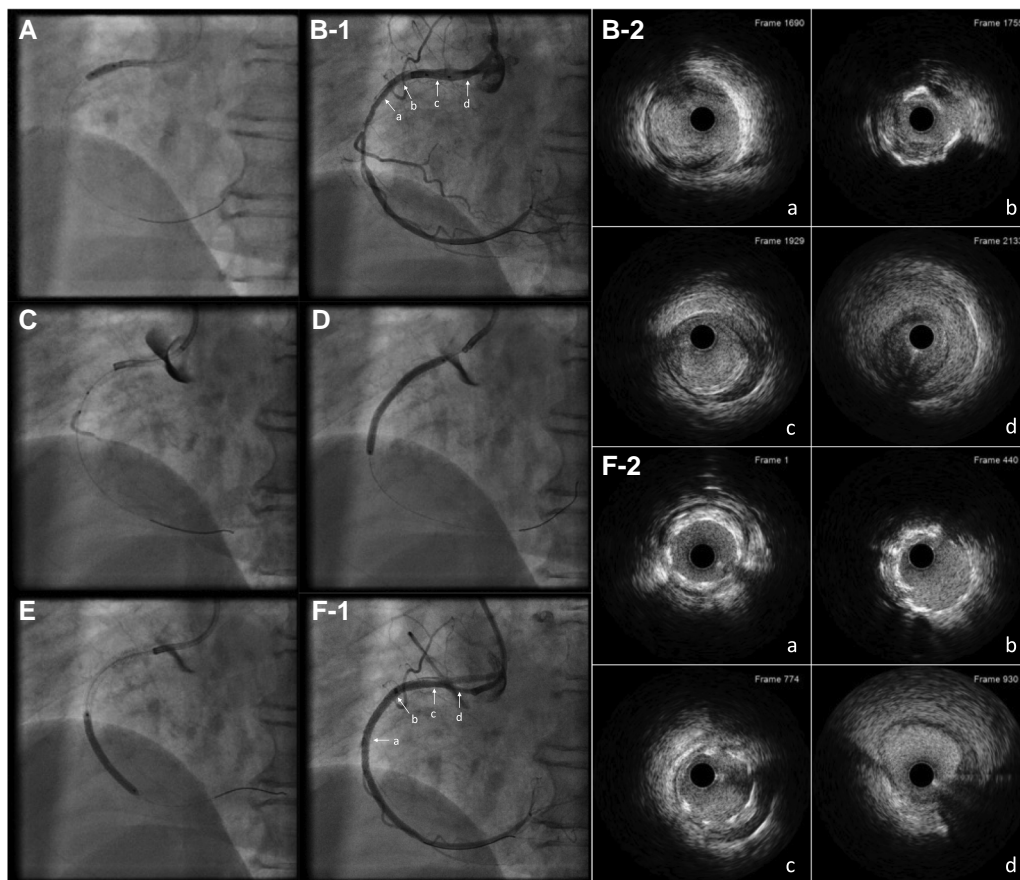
Elective percutaneous coronary intervention for the residual right coronary artery (RCA) lesions. (A) A 3.0×8 mm non-compliant balloon inflation for the narrowed proximal RCA. (B-1) After balloon inflation. Angiography showing coronary dissection of the proximal RCA. (B-2) Intravascular ultrasound (IVUS) images. Longitudinal intraluminal tear at the proximal RCA with an accompanying aortocoronary intramural haematoma. Right coronary artery ostium has a circumferential haematoma. (C) After a 2.0×8 mm non-compliant balloon inflation for the mid-RCA. Angiography showing an aortocoronary dissection extending to the right coronary cusp and new coronary dissection of the right ventricle branch. (D) A 2.75×38 mm drug-eluting stent (DES) is deployed at the proximal RCA. (E) A 2.5×38 mm DES is deployed at the mid-RCA. (F-1) Final angiography showing good coronary flow except for the right ventricle branch, with a remaining aortocoronary dissection. (F-2) The IVUS showing an expanded stent-lumen area.
